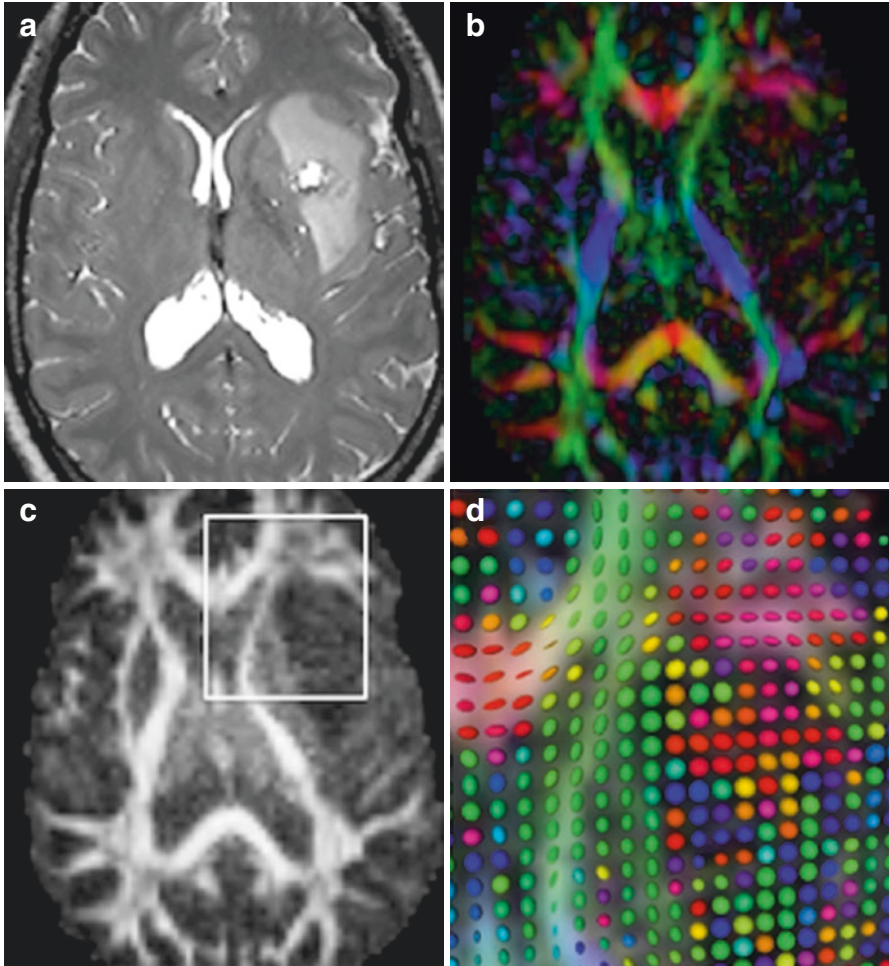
Pre-operative structural and diffusion MRI data in an astrocytoma grade II. (a) T2-weighted image; (b) Directionally encoded color (DEC) map; (c) Fractional Anisotropy (FA) map; (d) zoomed-in view of DTI glyphs superimposed on FA and DEC map. The view presented in (d) corresponds to the region of interest (*white*) outlined in (c).
